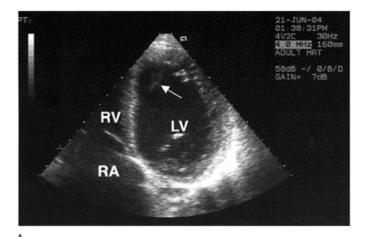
True aneurysm. (A) Apical aneurysm: apical four-chamber view. Note abnormal geometry of the apex in diastole. (B) Inferior aneurysm: parasternal long-axis (B.1) and short-axis (B.2) views. Arrows indicate typical broad neck of the aneurysm.
